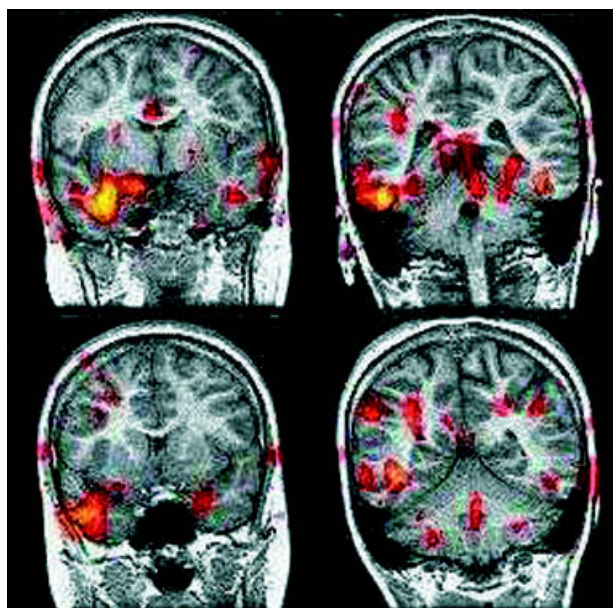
Ictal single-photon emission computed tomography subtraction images, obtained by subtraction, normalization, and coregistration (see earlier figures), show temporal and occipital areas of increased perfusion in a patient with epilepsy in the occipitotemporal network.
